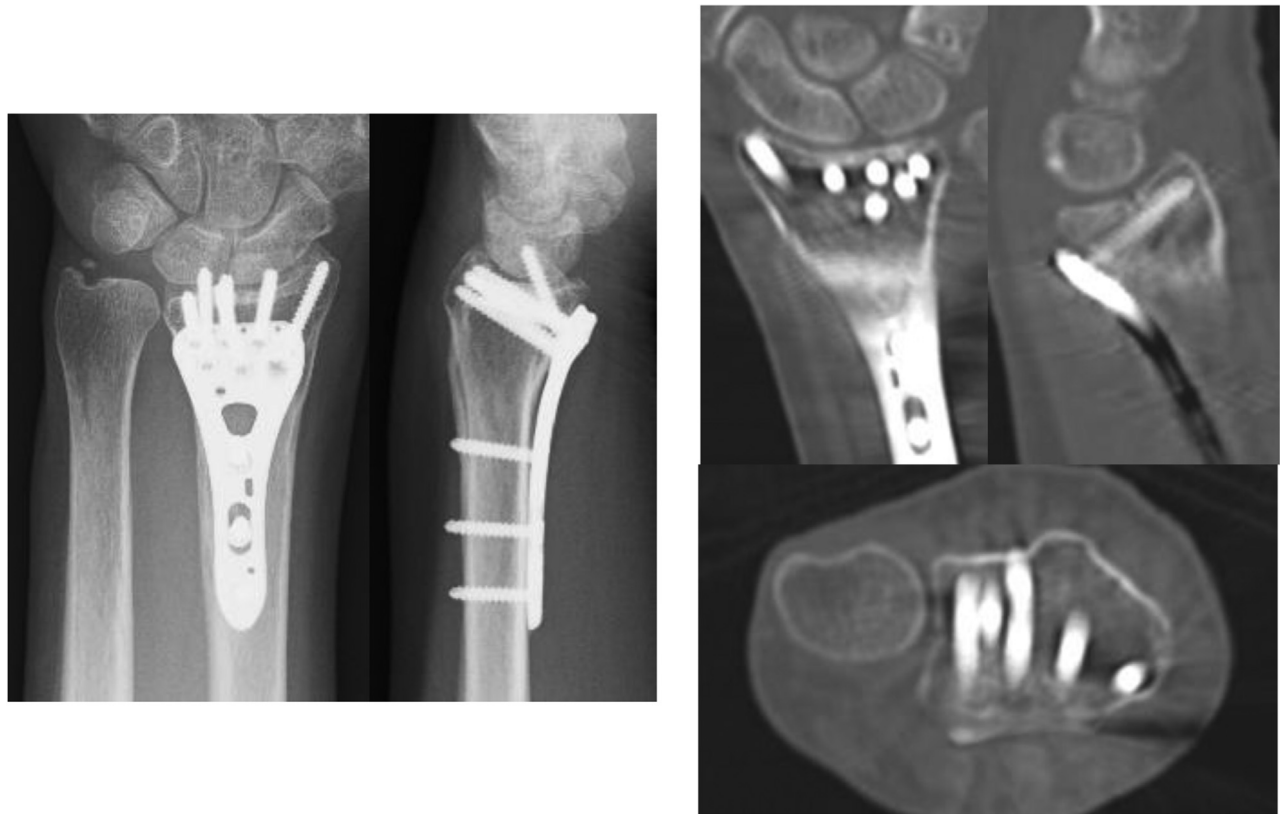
Radiographic and CT images at post-bone union.
